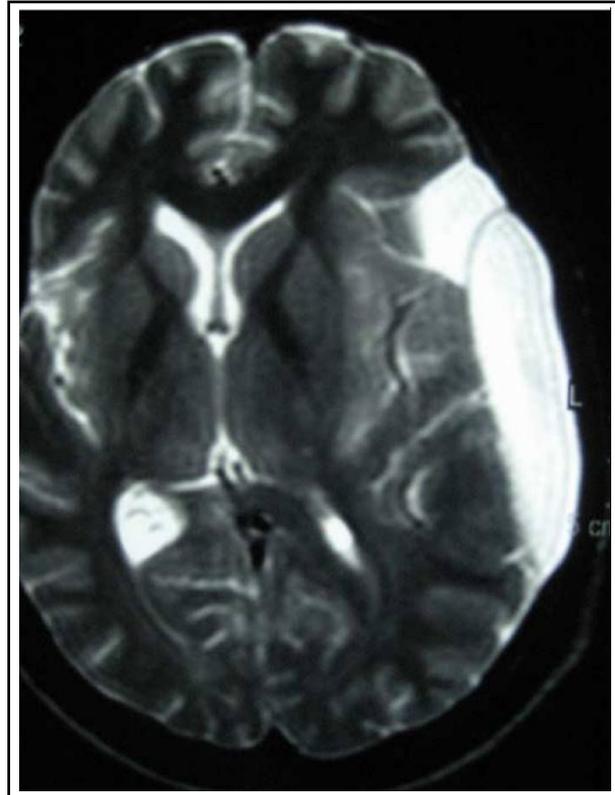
MRI showed arachnoid cysts on the anterior of left temporal region that is isointense with CSF, anterior of left temporal lobe was hypoplastic, on the left frontotemporoparietal localization; a mass was observed which showed no contrast on the application of paramagnetic contrast substance and isointense with CSF.
